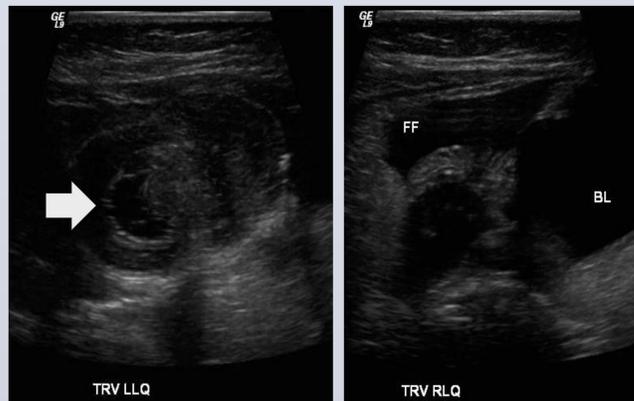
Ultrasound images demonstrating concerning signs on intussusception such as trapped fluid (arrow) and free fluid (FF). These findings on ultrasound indicated a higher risk of unsuccessful reduction of intussusception by therapeutic enema.
